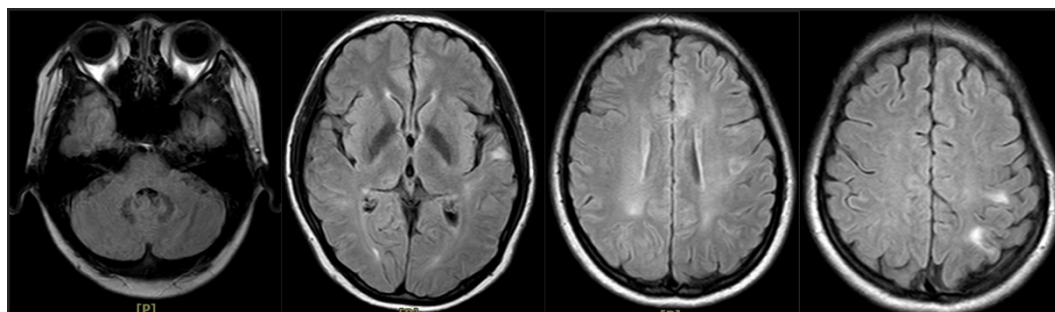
MRI head with contrast (FLAIR sequences) three weeks on immunosuppressive and immunomodulatory therapy. Chronic ICH are noted in bilateral thalamus, left cerebellum, bilateral parietal lobes (predominantly on the left side), and the left temporal lobe. No post-contrast enhancement. The appearance relatively unchanged since previous last examination. No perifocal edema is observed.
